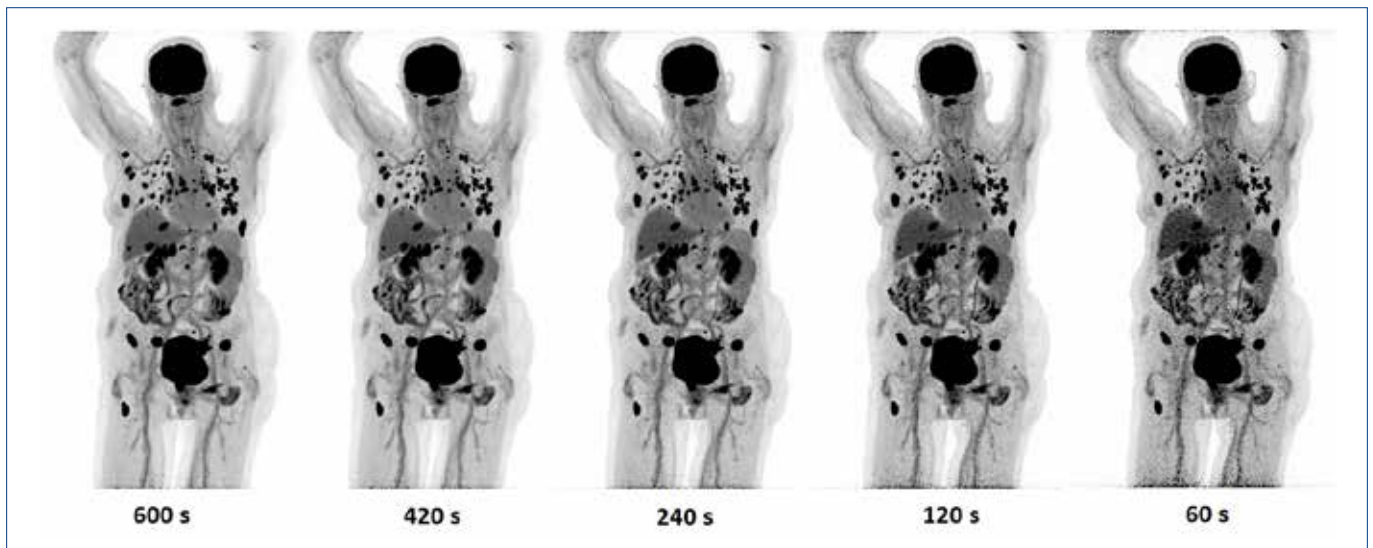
Maximum intensity projection images of an 85 year old female patient with metastatic breast cancer who received a weight-based (81 kg) injection of 240 MBq [ $^{18}\text{F}$ ]FDG activity and underwent a single LAFOV Quadra PET/CT scan of 10 min. Scans were acquired in listmode at 60 min. post injection and reprocessed to reconstruct additional images for shorter scan durations. No Gaussian smoothing was applied during reconstruction of these images.
